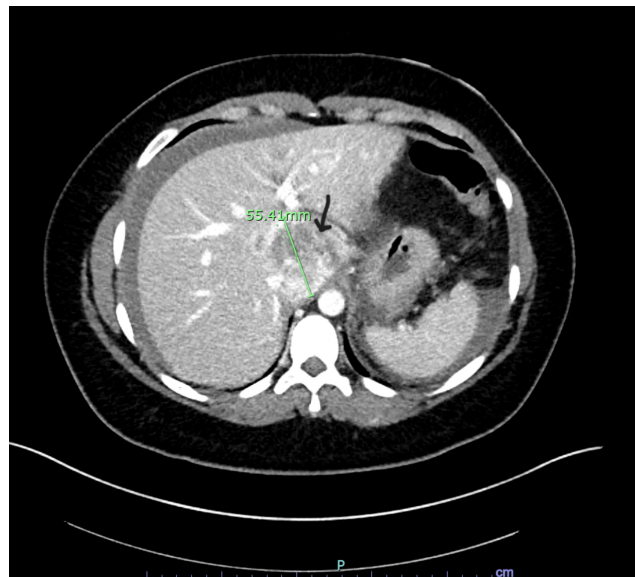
CT of the abdomen and pelvis with IV contrast: A large heterogeneously enhancing mass (black arrow) is centered in the caudate lobe, measuring approximately 5.5 cm. This mass appears to have ruptured with associated hemoperitoneum. Evaluation for active extravasation is somewhat limited on this single-phase scan; however, based on the appearance, active hemorrhage is suspected.
